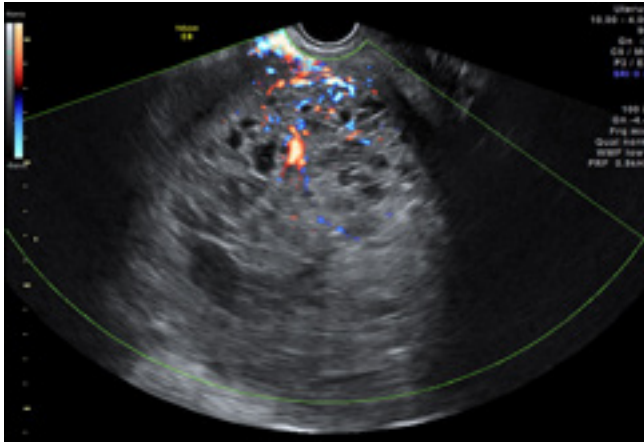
Sarcoma. Mixed echogenicity, richly vascularized, grade 4 color Doppler lesion
